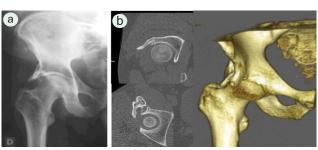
A. Conventional radiography showed the pelvic digit adjacent to the right hip. B. Computed tomography including the coronal view (up), the saxial view (down) and the tridimensional reconstruction.
